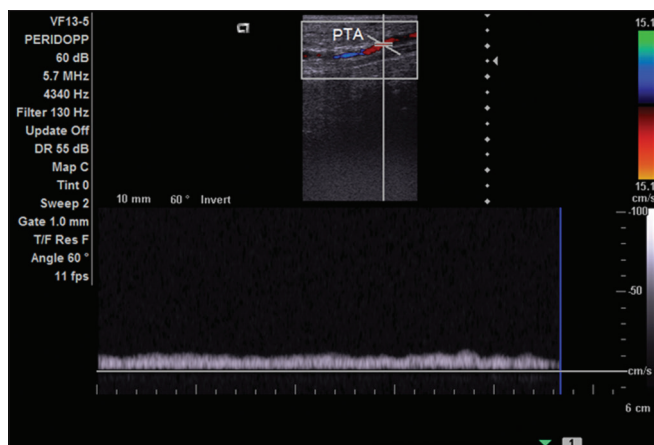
Longitudinal color Doppler image of post-thrombotic posterior tibial artery showing monophasic waveform
